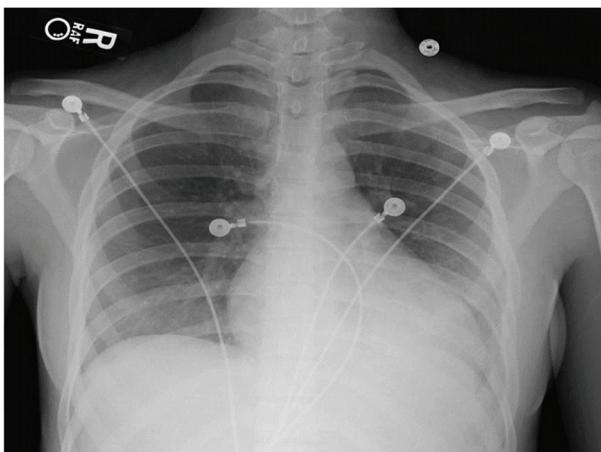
Chest X-ray showing hazy bibasilar opacities suggestive of atelectasis.
